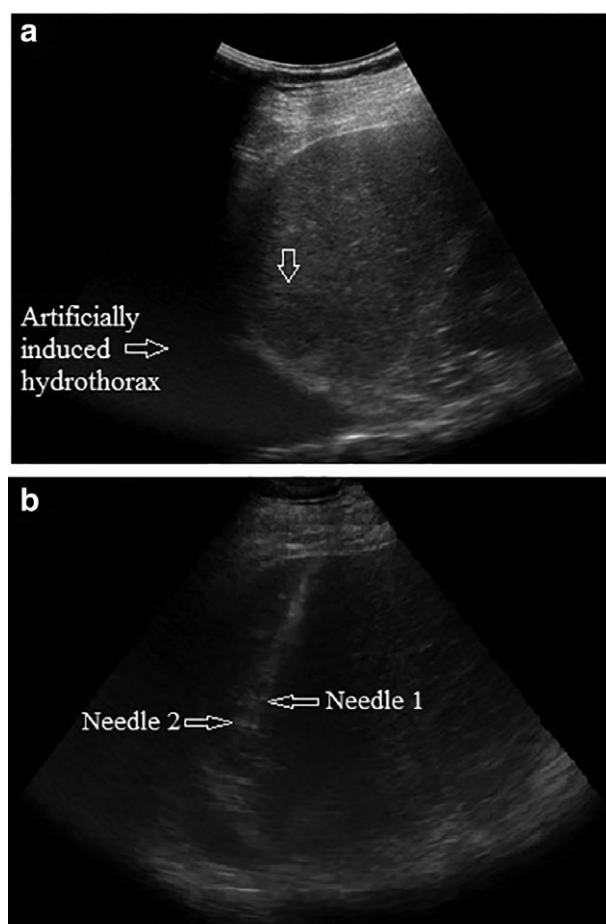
A hypoechoic lesion in the right posterior segment of the liver was detected by ultrasonic examination. (a) Artificially induced right hydrothorax to make the ultra sound-image clear and protect the lung from active heating. (b) Ablative needles were advanced into the upper and lower sides of the lesion.
